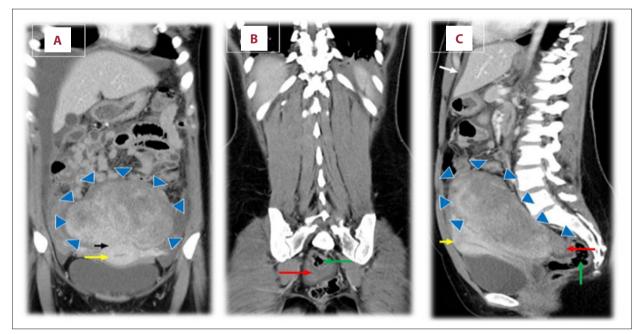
Abdominal contrast-enhanced computed tomography (CT) imaging. (A, B) Coronal view. (C) Sagittal view. The blue arrow indicates a heterogenous uterine mass measuring 8×12 cm. The black arrow indicates the origin from the uterine fundus. The yellow arrow indicates the uterus. The green arrow indicates the lumen of the rectum. The red arrow indicates a pedunculated stalk attached to the rectal serosa. The white arrow indicates peritoneal fluid with an imaging density suggestive of blood.
